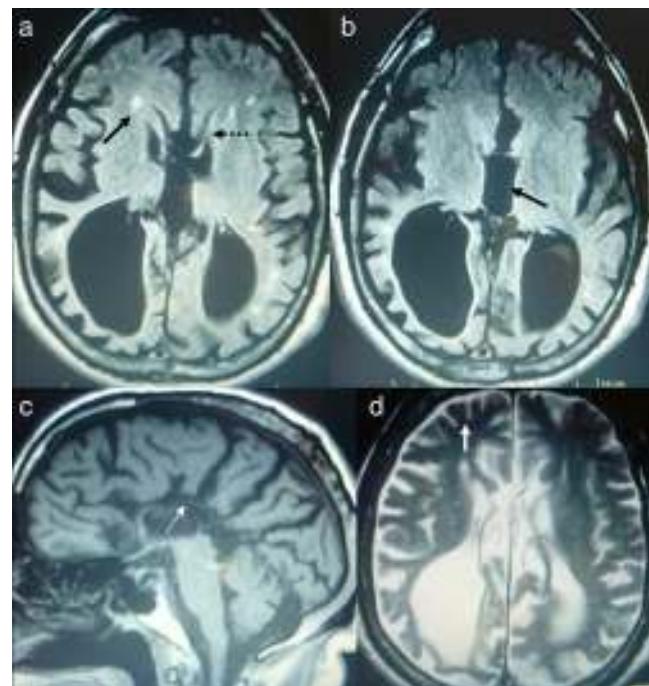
Head MRI scan of case 1. a) Axial FLAIR sequence. Frontal ventricles (dotted arrow) are small, and the frontal parenchyma features small hyperintense images (arrow) that could be associated with arterial hypertension. The third ventricle and occipital horns are dilated (CC). b) Axial FLAIR sequence. The third ventricle appears dilated (arrow) and the upper part of the corpus callosum is very thin. c) T1-weighted sagittal slice: the genu and trunk of the corpus callosum (arrow) seem faint. The fourth ventricle is normal-sized. d) T2-weighted axial slice. Frontal sulci are much smaller than cortical sulci on the posterior part of the brain.
